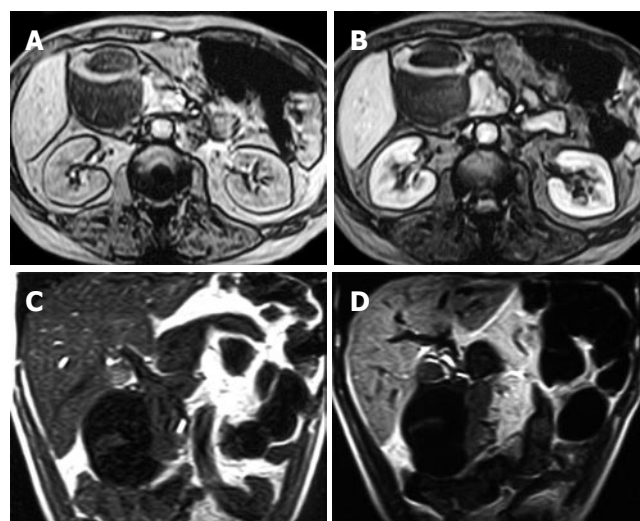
Unenhanced (A) and MnDPDP-enhanced (B) axial T1-weighted GRE images, unenhanced (C) and MnDPDP-enhanced (D) coronal T1-weighted SE images in pancreatic parenchyma out of lesion and liver parenchyma after MnDPDP infusion. Minimal contrast enhancement in the septa of mass was found on MnDPDP-enhanced images (B and D).
